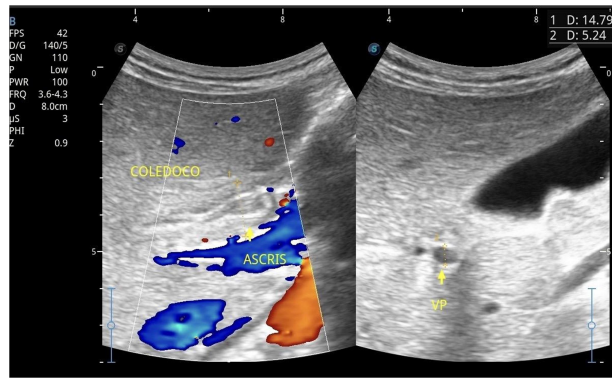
Abdominal ultrasound showing a dilated common bile duct containing a tubular, hyperechoic structure consistent with *Ascaris lumbricoides* (triple-line sign), indicative of biliary ascariasis.
